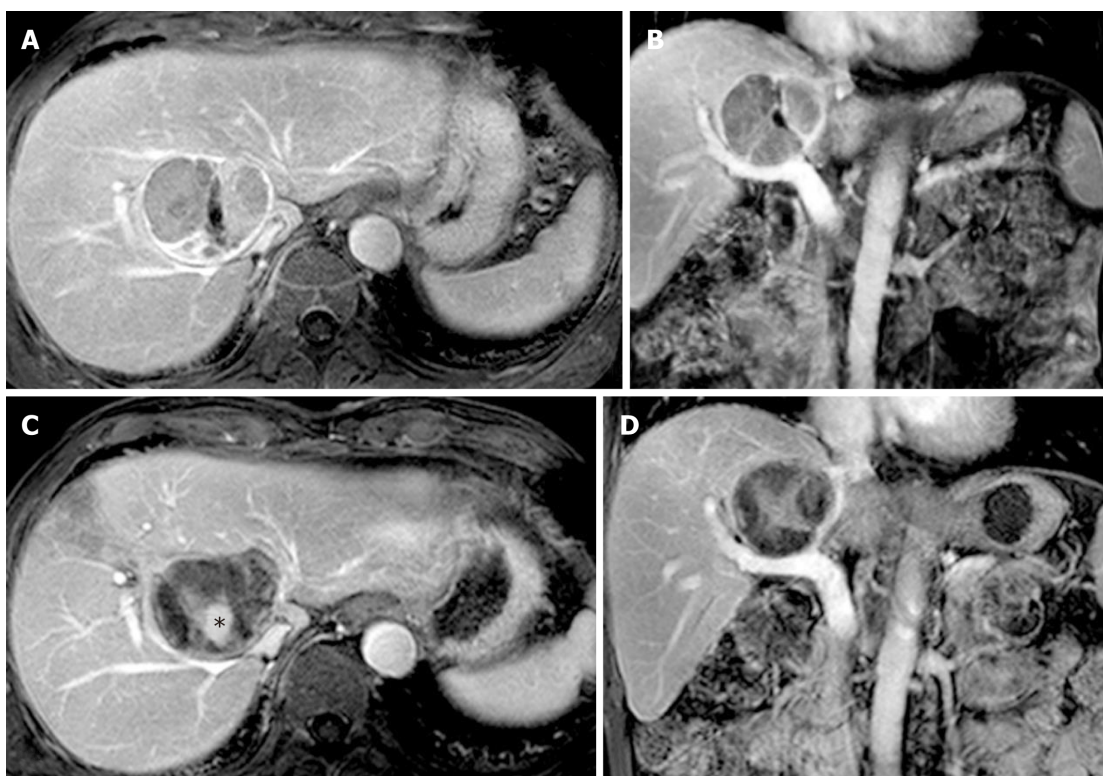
A well-defined active caudate lobe tumor adjacent to the right hepatic vein in a 69-year-old man with a history of tongue cancer after two sessions of TACE. A and B: The enhanced part was predominant and had poor lipiodol deposition consistent with active tumor tissues; C and D: Post-contrast magnetic resonance imaging (MRI) images after HRFA therapy show a non-enhanced mass with hypointensity. The central irregular hyperintensity (black asterisk, C) was caused by the hemorrhagic content of the necrotic cavity, rather than by contrast enhancement. Relapse was not detected in the most recent MRI examination (data not shown).
